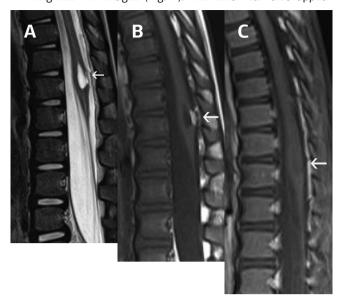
Intramedullary dermoid tumor. A 3-year-old female patient with previous history of occult spinal dyraphism. Sagittal MRI of spine: T2-weighted (A), T1-weighted (B) and gadolinium-enhanced fat-suppressed T1-weighted images (C). There is a well-defined intramedullary cystic mass, expanding the dorsal spinal cord. The dorsal component (arrows) is hyperintense on T1-weighted and T2 -weighted images and shows suppression on gadolinium-enhanced fat-suppressed T1-weighted MR image, consistent with fat.
